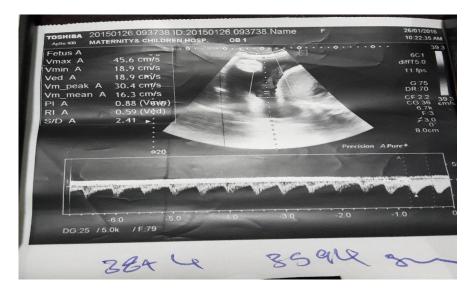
shows normalColor Doppler of the umbilical artery waveform at 38 Wks
